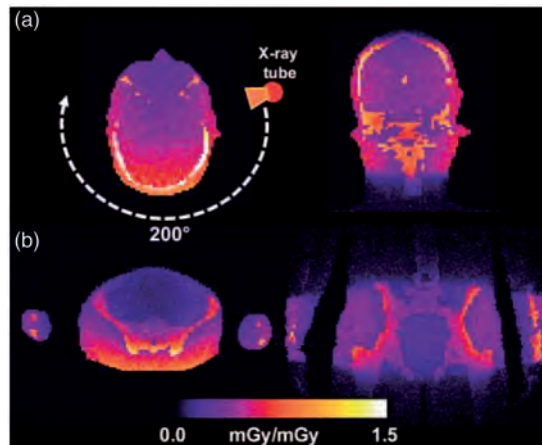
In contrast to multi-detector computed tomography, cone beam computed tomography is mostly performed with a half scan angle ( $180^\circ$  plus cone angle). As such, the position of the scan angle has a significant influence on the dose distribution within the patient (Kyriakou et al., 2008a).
